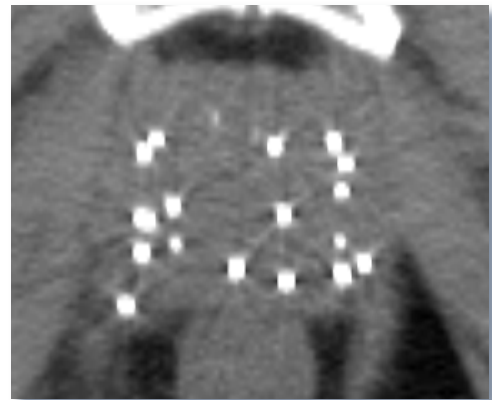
CT image of the prostate indicates the limitation as it shows the low soft tissue contrast in the image.
